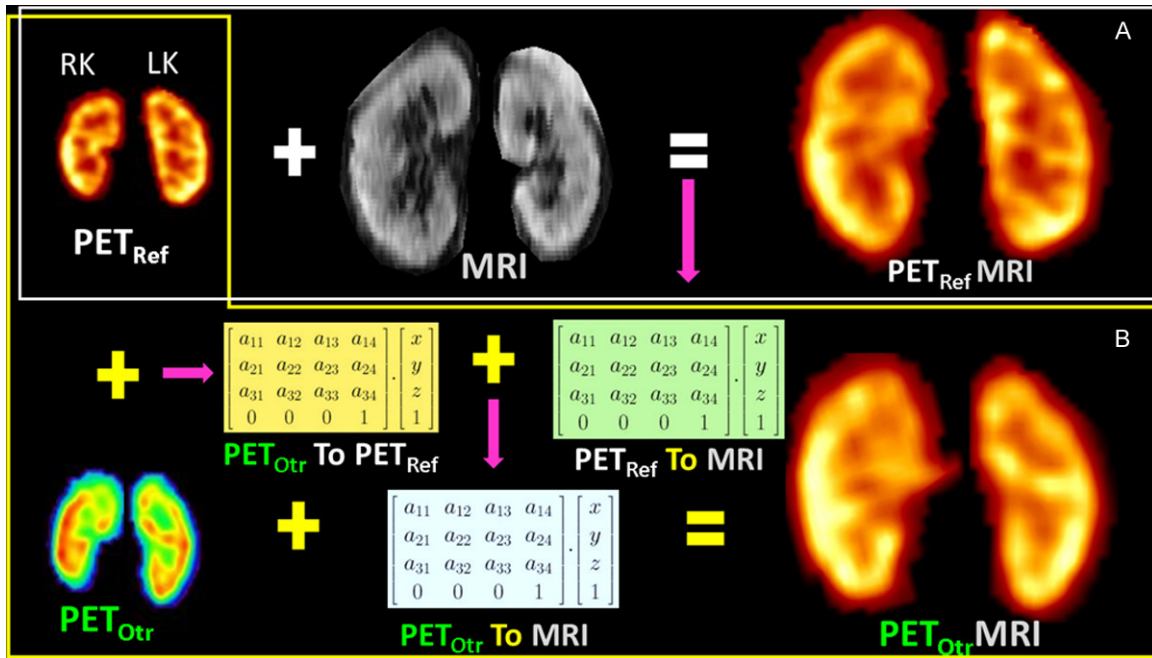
A. PET image was directly normalized to the template (MR image), where both PET_{Ref} and MR images were from the same subject (reference subject). B. PET image was normalized to the template through an intermediate PET space registration process, where PET_{Otr} images of other subjects were registered to the reference subject's PET_{Ref} image, then the transformation matrix obtained from this process (PET_{Otr} To PET_{Ref}) was concatenated with the transformation matrix obtained from process-A (PET_{Ref} To MR) and finally the resultant transformation matrix (PET_{Otr} To MR) was applied on PET_{Otr} image of other subjects to get the normalized image.
